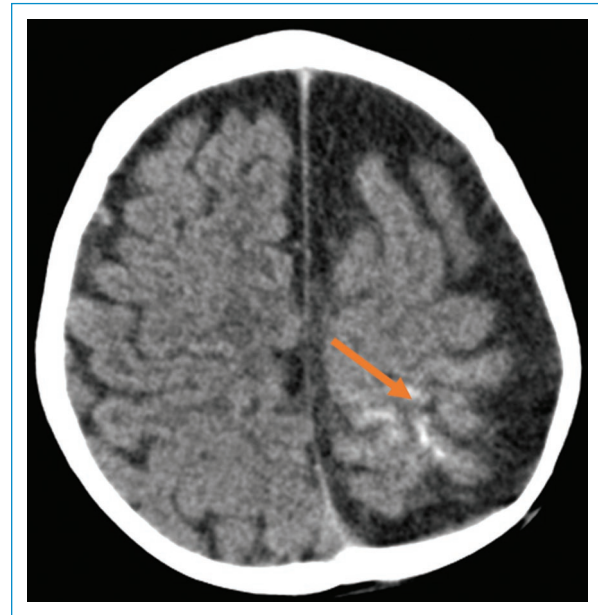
CT image with left cerebral atrophy with associated subcortical calcifications (arrow).
